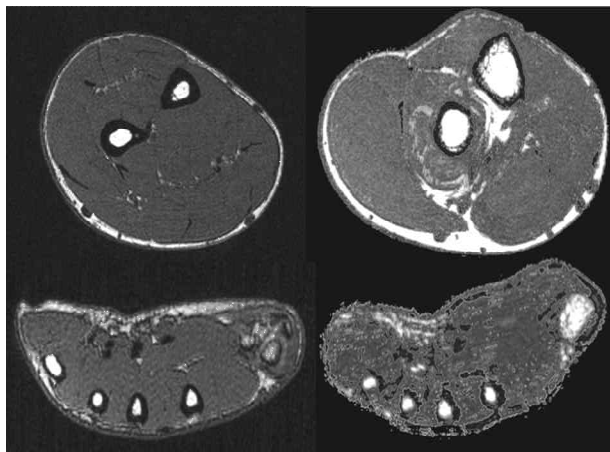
MR images showing the cross sectional slices of the forearm(top) and the hand(bottom). The images on the left are raw files prior to segmentation to differentiate various tissues. The images on the right show different tissues defined by different colors. The tissue of interest, muscle, is shown with the red border.
